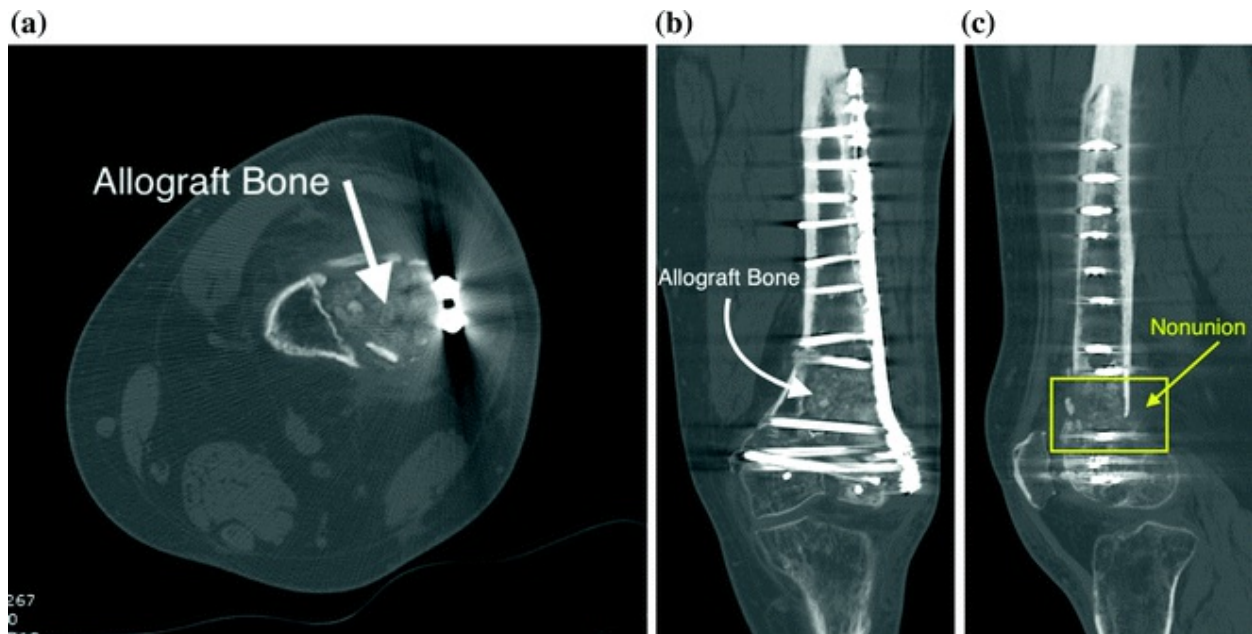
A computed tomography scan was obtained to evaluate the fracture site. a Axial image showing the allograft bone still unincorporated and a lack of bridging; b coronal image showing again the allograft bone and its lack of incorporation as well as subtle varus collapse; c the obvious nonunion is clearly visualized on the sagittal image
